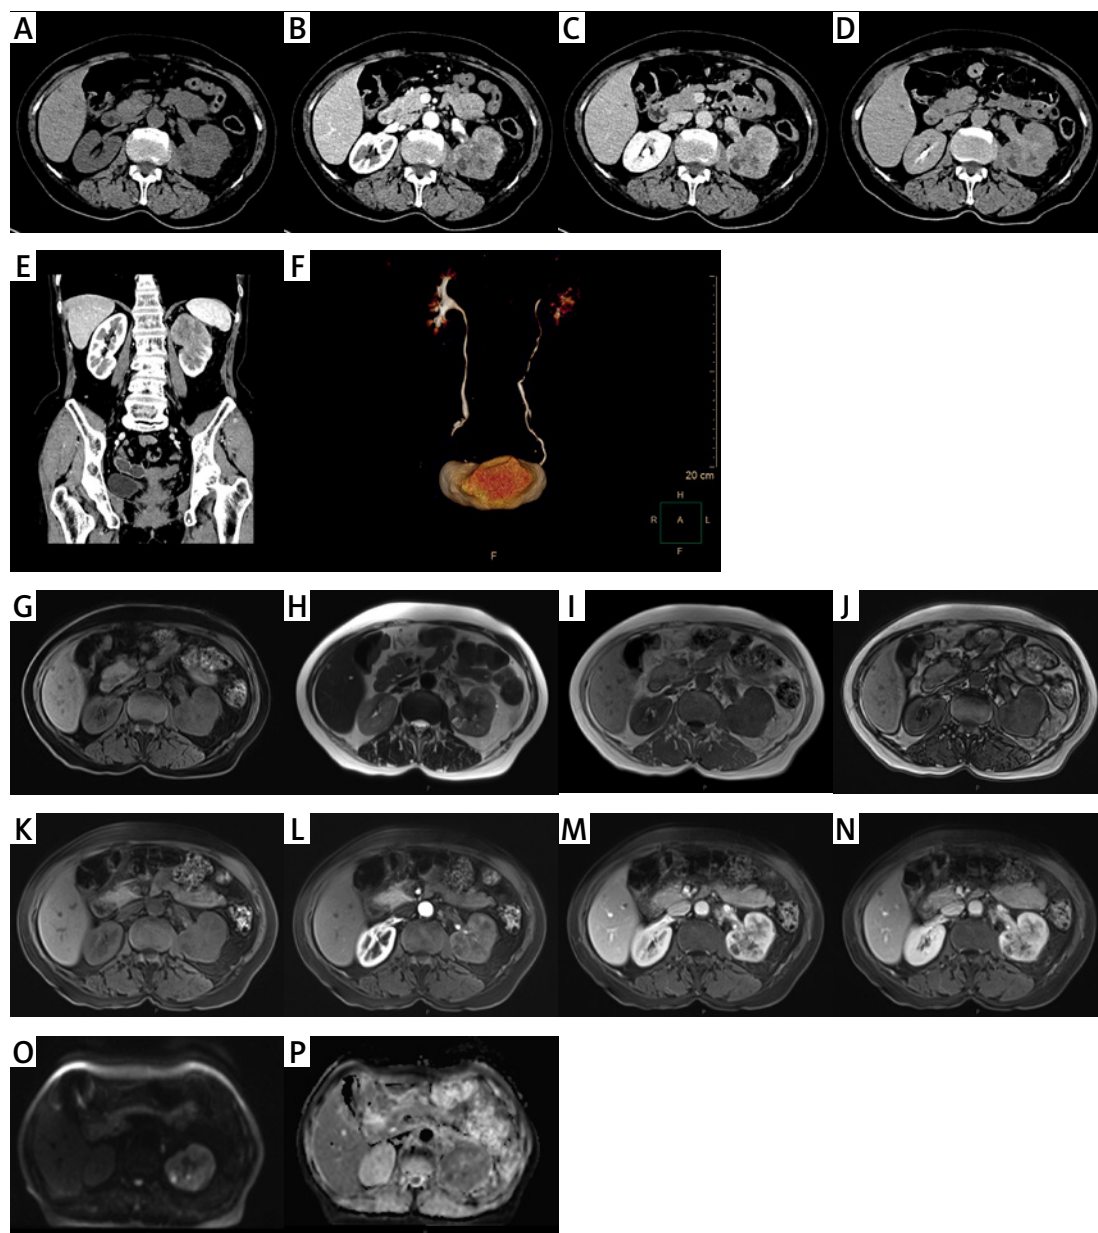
Representative computed tomography (CT), computed tomography urography (CTU) and magnetic resonance imaging (MRI) images of the patient: A – Non-contrast abdominal CT scan axial image shows an irregular, slightly hyperdense mass in the left mid-to-upper kidney, with heterogeneous density. B – Artery phase, contrast-enhanced scan shows marked heterogeneous enhancement with small nodular non-enhancing foci. C – Venous phase, the left renal vein shows a suspected filling defect. D – Excretory phase shows no abnormal density in the bilateral ureteral courses. E – Coronal view shows a slightly hyperdense mass with heterogeneous density in the upper pole of the left kidney, with parenchymal invasion and ill-defined margins. F – CTU shows contrast opacification in bilateral pelvises, calyces, and ureters. The left kidney demonstrates heterogeneous, reduced contrast filling compared to the right. The ureter is fully visualized without significant dilation or stricture. G – Axial T1-weighted non-contrast image shows an irregular lesion in the left renal parenchyma with isointense signal. H – Axial T2-weighted non-contrast image shows the lesion with slightly hyperintense signal. I – Axial T1-weighted in-phase image. J – Axial T1-weighted opposed-phase image. K – Axial T1-weighted pre-contrast mask image. L – Axial T1-weighted arterial phase image shows low signal intensity in the left kidney and indistinct renal pelvis. M – Axial T1-weighted venous phase image shows heterogeneous signal in the proximal renal vein. N – Axial T1-weighted excretory phase image. O – Diffusion-weighted imaging (DWI) shows restricted diffusion, with nodular markedly hyperintense signals in some cystic components. P – The corresponding apparent diffusion coefficient (ADC) map shows slightly decreased ADC value
